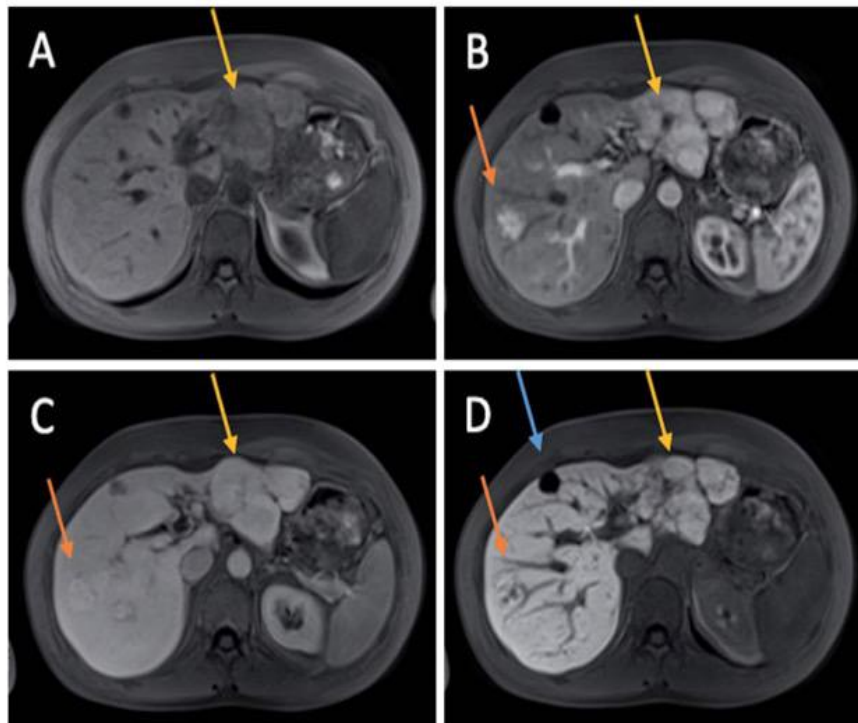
Same patient as in Figures 3 and 4. MRI of two FNH lesions, one on the left liver lobe (yellow arrows; 7.8 cm, showed in Figures 3 and 4) and the other one in segment 8 (orange arrows; 3 cm) with the same pattern characteristics. Sequences are fat saturated. T1-weighted sequences without (A) and after (B-D) contrast agent. A: Moderately hypointense lesions in native T1 weighted sequence. B: Intense enhancement of the lesions in the late arterial phase. Hypointense central scar of the lesion on the left liver lobe (yellow arrow). No central scar in the second lesion (orange arrow). C: Isointense enhancement of the lesions on portal venous phase relative to the liver parenchyma. D: FNH lesions fade toward background liver intensity on the delayed hepatobiliary phase and show an homogeneous appearance with enhancement remaining; hypointense enhancement if compared to the liver parenchyma. Except for the central scar. Liver cyst (blue arrow).
